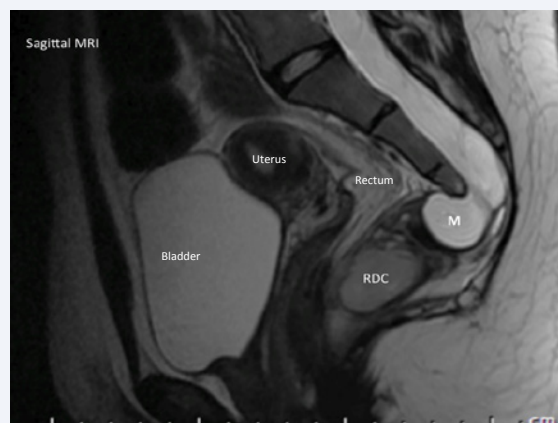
Mid-sagittal MRI demonstrates the rectal duplication cyst posterior to the rectum (RDC).
